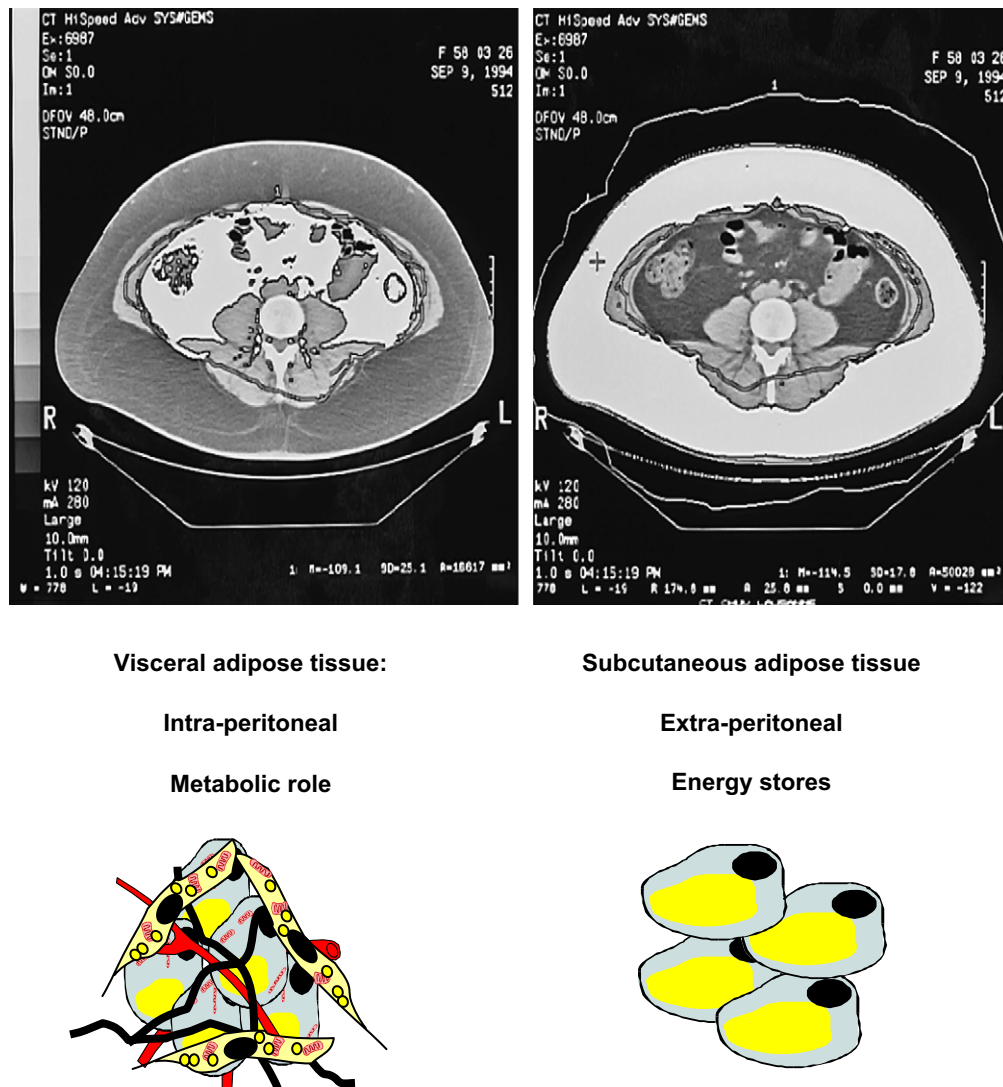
This CT scan performed at the abdominal level to show the distribution of the visceral and subcutaneous adipose tissue. There are very important differences in morphology, physiology, metabolic activity and hormonal sensitivity between the two compartments. The visceral adipose tissue compartment has especially a metabolic role, while the abdominal subcutaneous compartment has rather a function of energy store.
